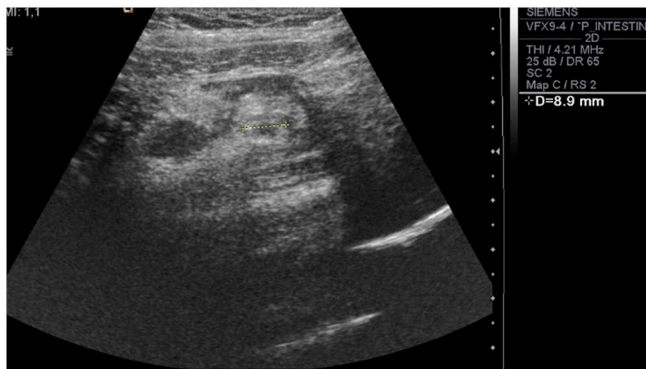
Longitudinal ultrasound scan showing a tubular blind-ended structure and surrounding fluid.
